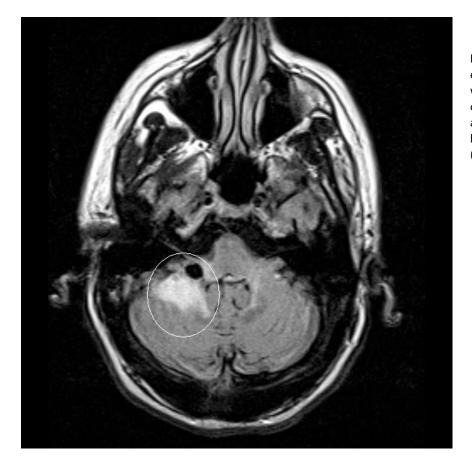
An MRI scan showing enhancement (lighting up when intravenous gadolinium contrast is administered) of a cerebellar brain sarcoidosis lesion (inside white circle). (from M. Judson)
